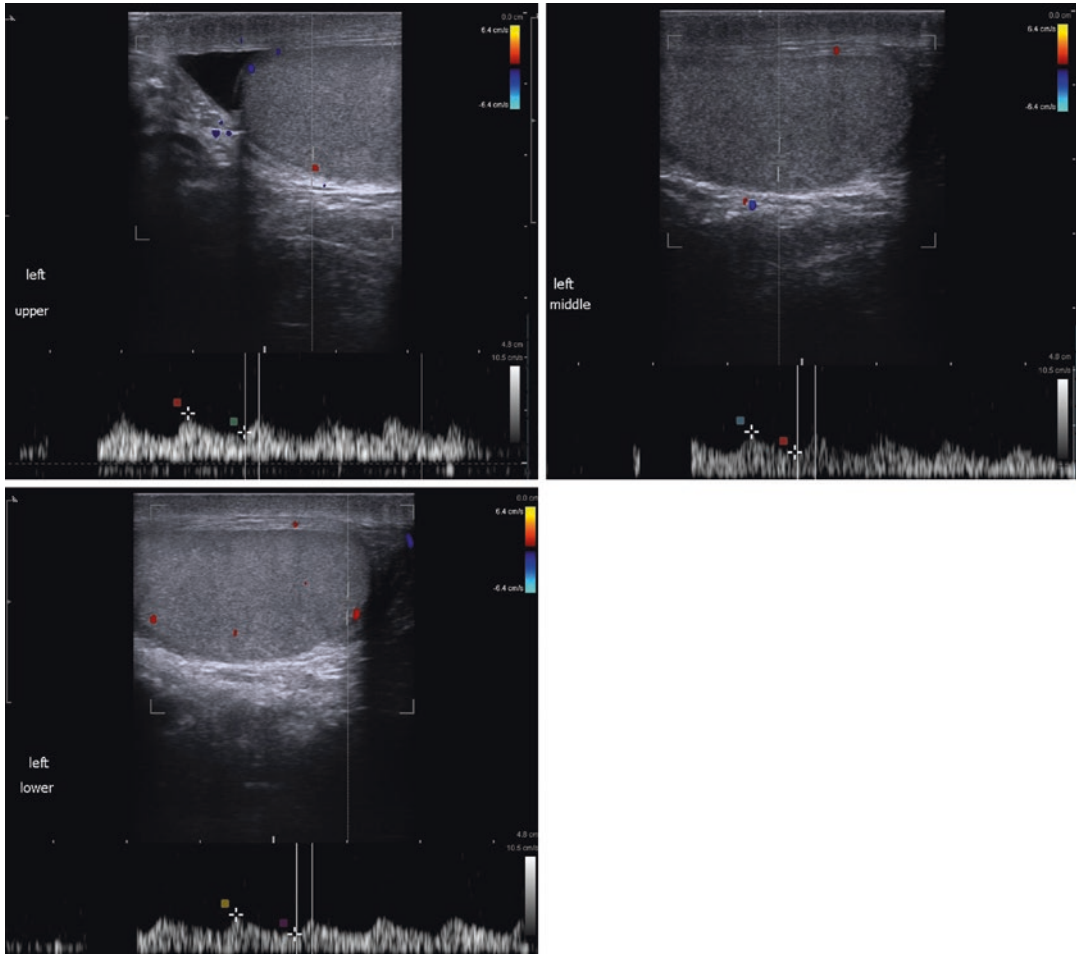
Spectral Doppler of left intratesticular arteries in the upper, upper-middle, and lower pole of the testis (single image view)
